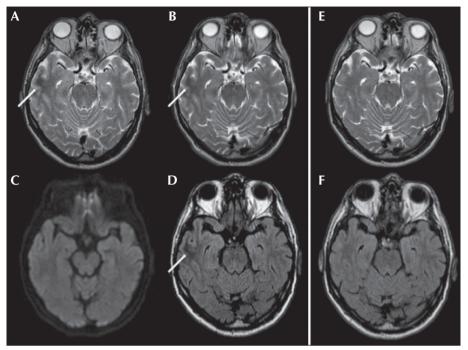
(A-D) Baseline MRI axial T2w with RL phase encoding (A), AP phase encoding (B), DWI b1000 (C), and FLAIR (D), showing right temporal subcortical hypointensity (arrows). (E, F) Follow-up MRI shows resolution of T2w hypointensity, with only a residual juxtacortical gliotic focus: axial T2w with RL phase encoding (E) and FLAIR (F). Images are shown in radiologic view (the right side of the brain is on the left side).
